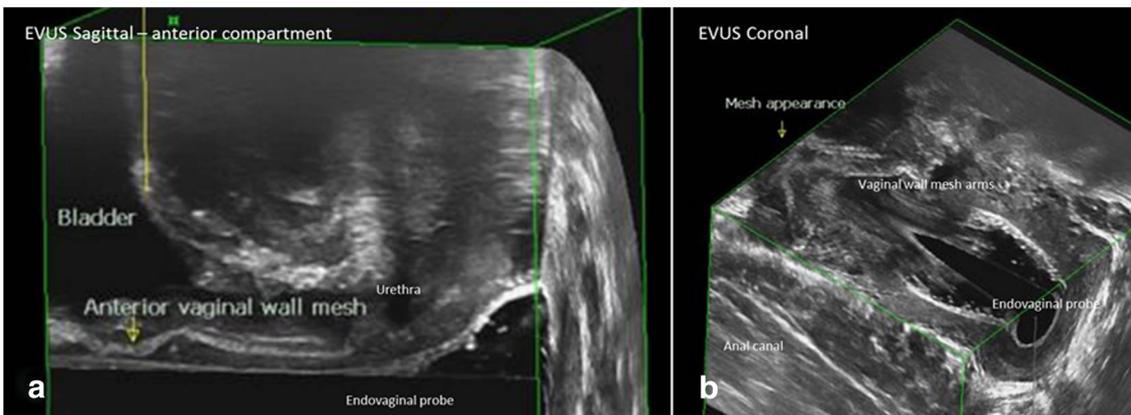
Vaginal wall mesh for pelvic organ prolapse. a Sagittal section on endovaginal ultrasound showing the scan from a woman who was unsure if she had mesh inserted at the time of anterior colporrhaphy. The mesh is
